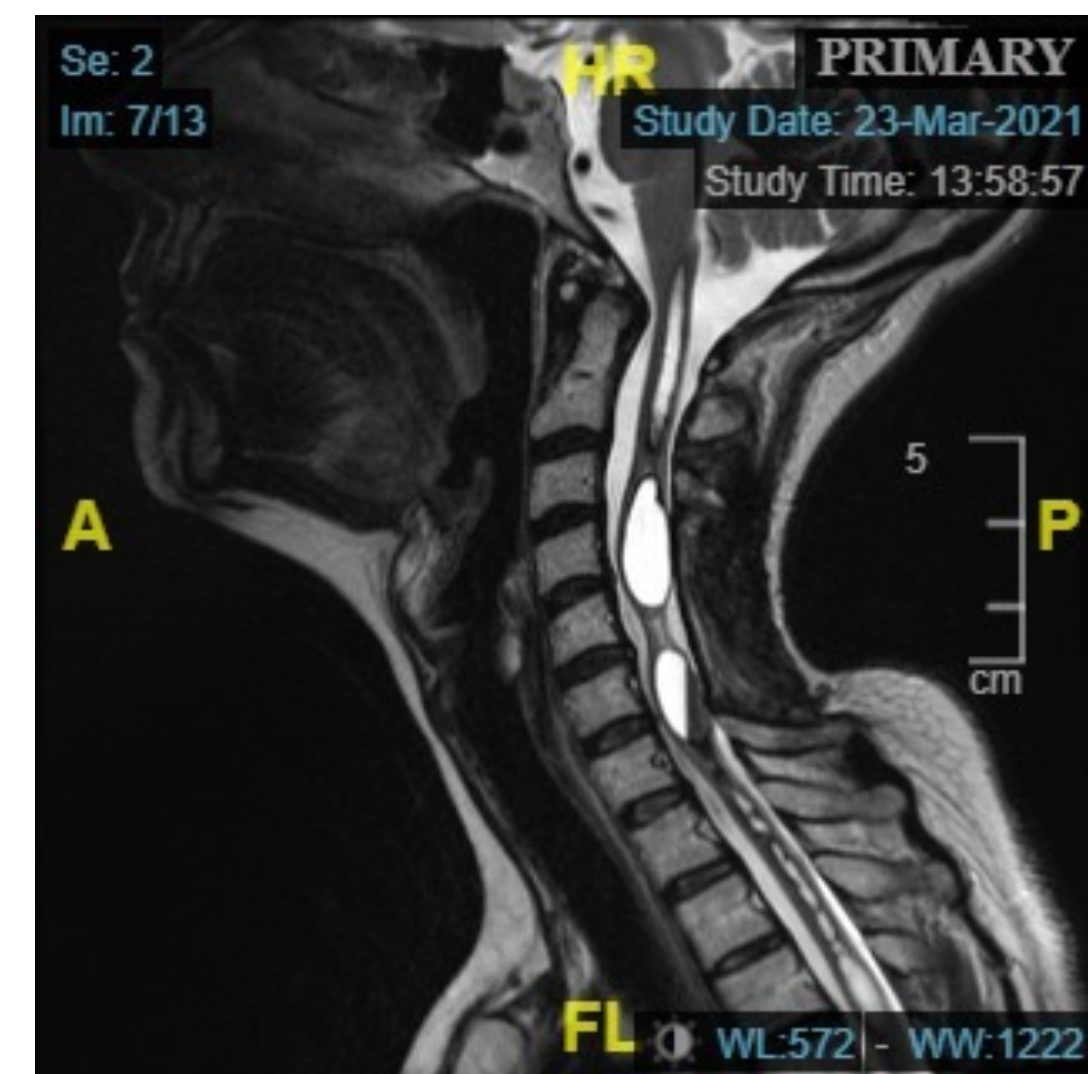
Cervical spine MRI showing a large syrinx extending from the cervico-medullary junction into the thoracic spine. At C4-C5 and C6 levels, the syrinx is much larger in volume. Findings consistent with prior multi-level posterior cervical laminectomy also noted.
